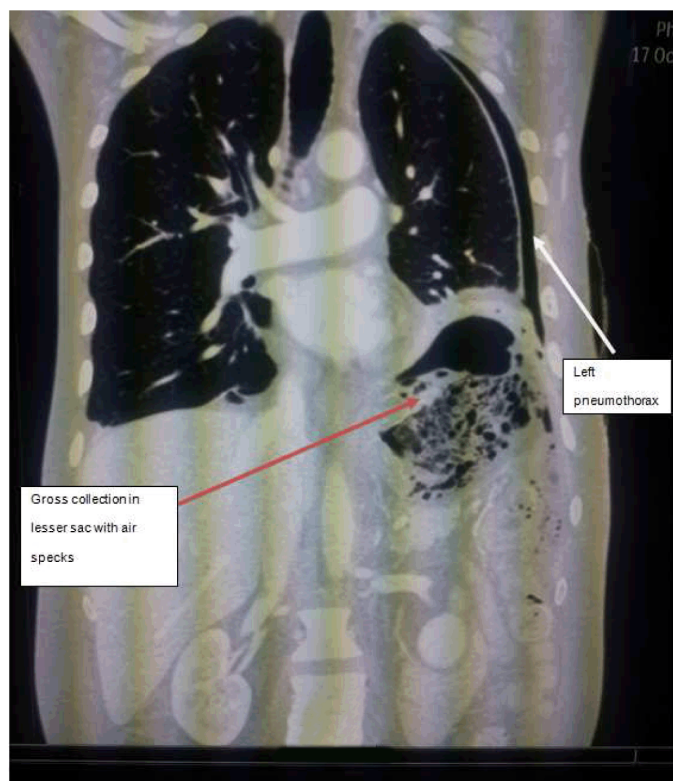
Contrast-enhanced computed tomography scan of chest abdomen and pelvis, coronal view, showing collection in the lesser sac with air specks and absent spleen with a left pneumothorax.
